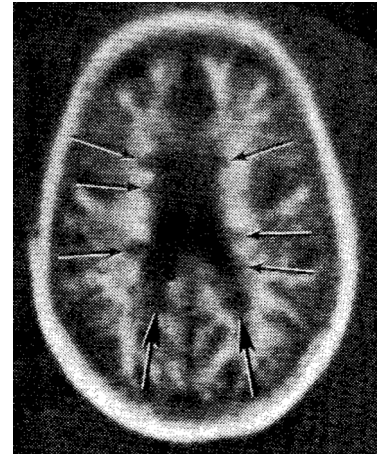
The first published brain MRI in MS visualizing multiple lesions (arrows) in an 18-year-old female with MS.⁵⁶
